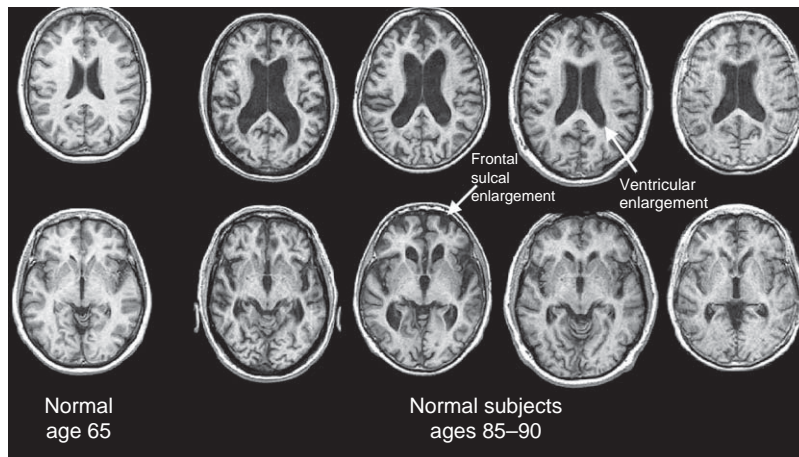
MRI in normal elderly and normal very old subjects. Note ventricular enlargement, frontal sulcal enlargement, and greater prominence of sulcal markings in very old subjects ages 85–90.
